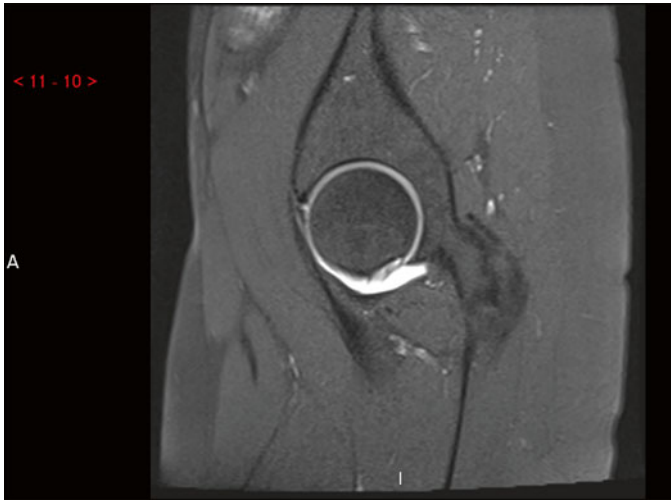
T2-weighted MR arthrogram showing contrast tracking between the acetabular rim and the labrum indicative of a labral tear.
